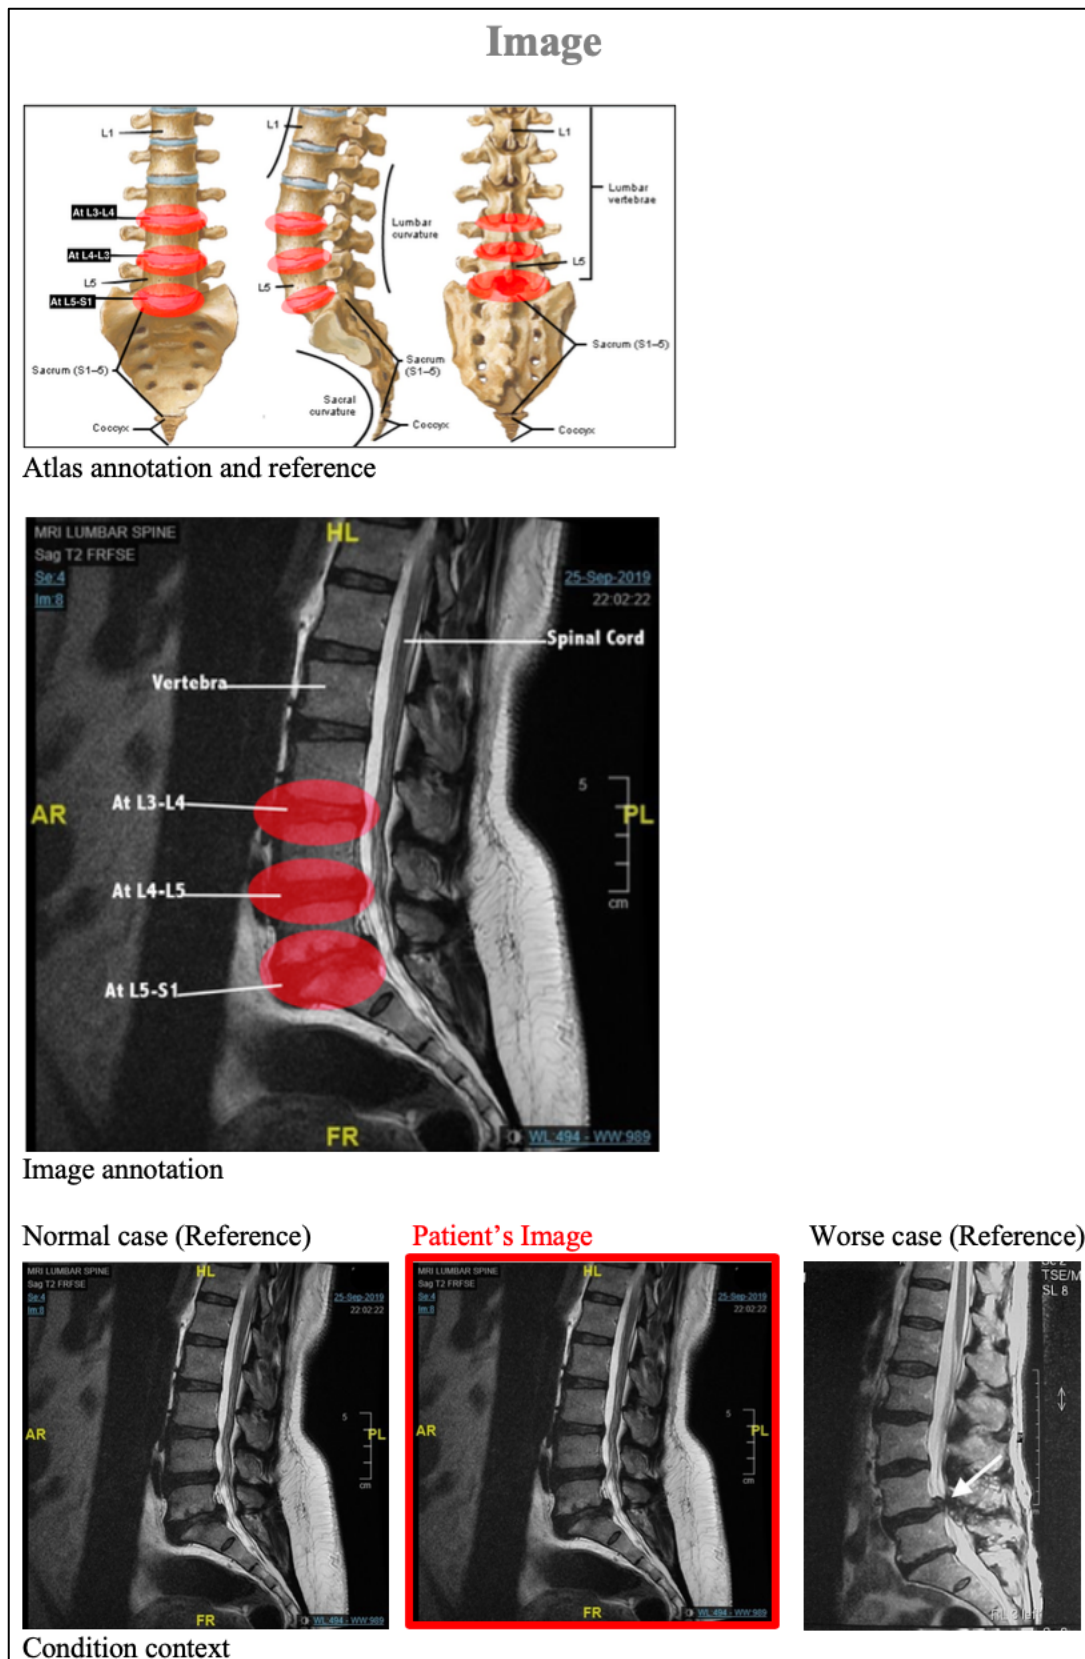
3. Revised design of the MRI Lumbar spine image
